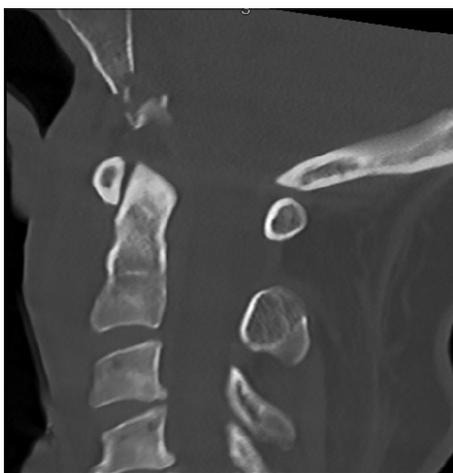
Computed tomography cervical spine (mid-sagittal view) shows the inferior clivus fracture.
